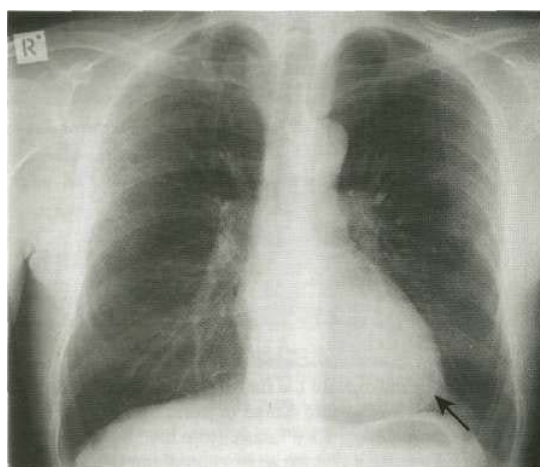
Chest X-ray showing a pericardial calcification (arrow).
